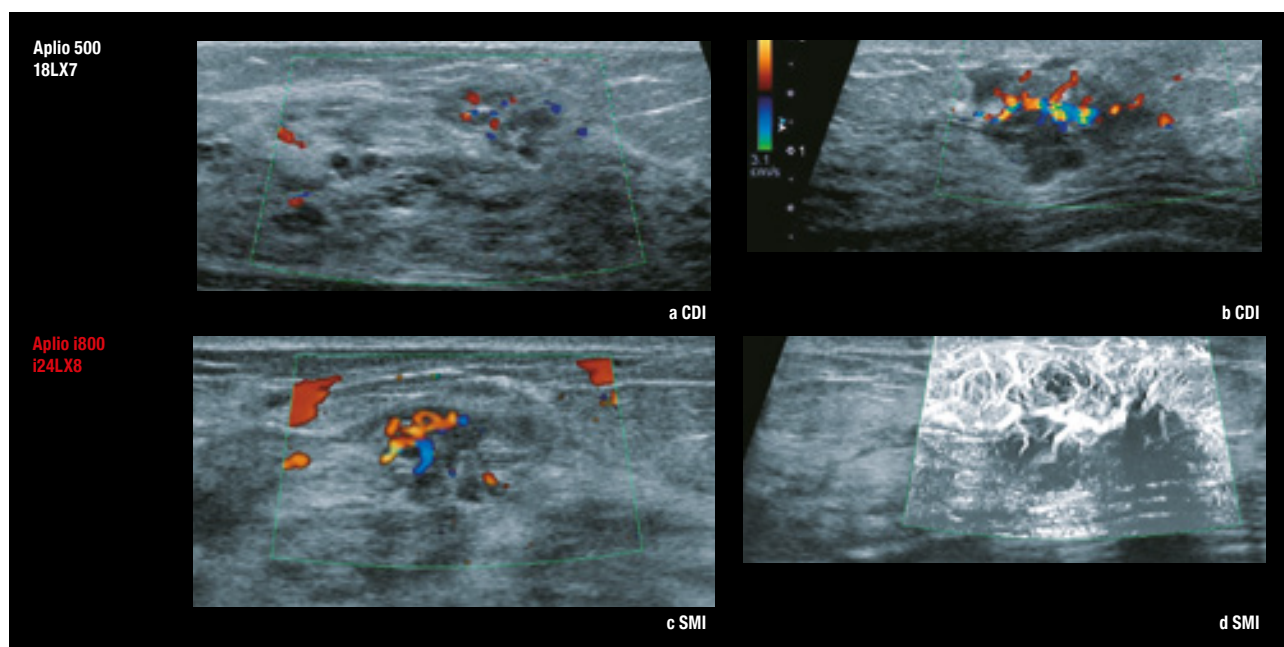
Comparison between 18LX7 (upper) and i24LX8 (lower) in color Doppler (a, b) and SMI mode (c, d).
